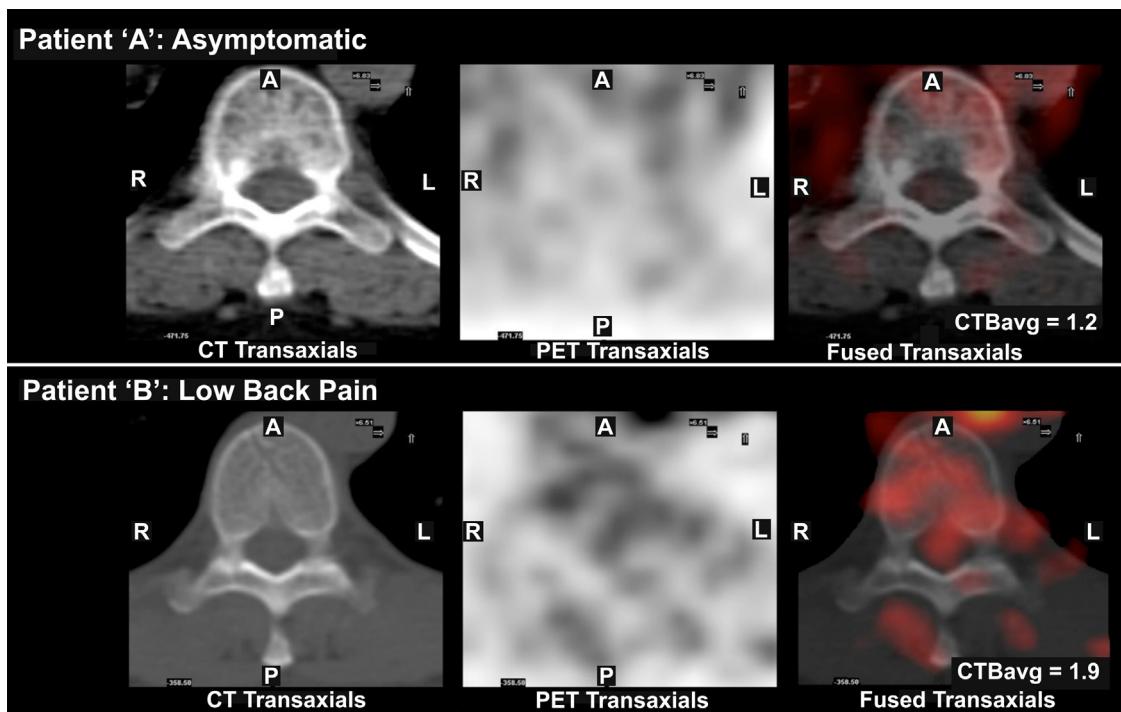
Representative transaxial ^{18}F -FDG PET/CT images at level T10 (at the mid-vertebral level) from Patient 'A', who was asymptomatic, and patient 'B', who described 'LBP' on the pre-study questionnaire. From left to right, a non-contrast CT, an attenuation corrected ^{18}F -FDG PET only, and an ^{18}F -FDG PET/CT fusion image have been provided for both patients. Increased radiotracer uptake is observed within the spinal canal of patient 'B' relative to patient 'A'. Calculated SUV from ROIs drawn within the spinal canal at this level (ROIs not shown) had values of 1.2 and 1.9 from Patients 'A' and 'B' respectively.
